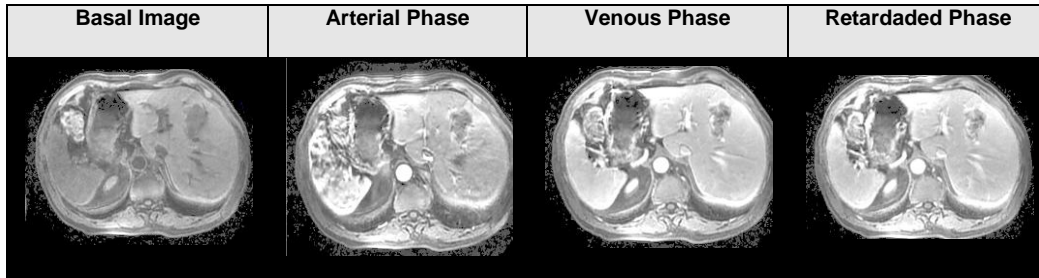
MRI contrast image sequence
